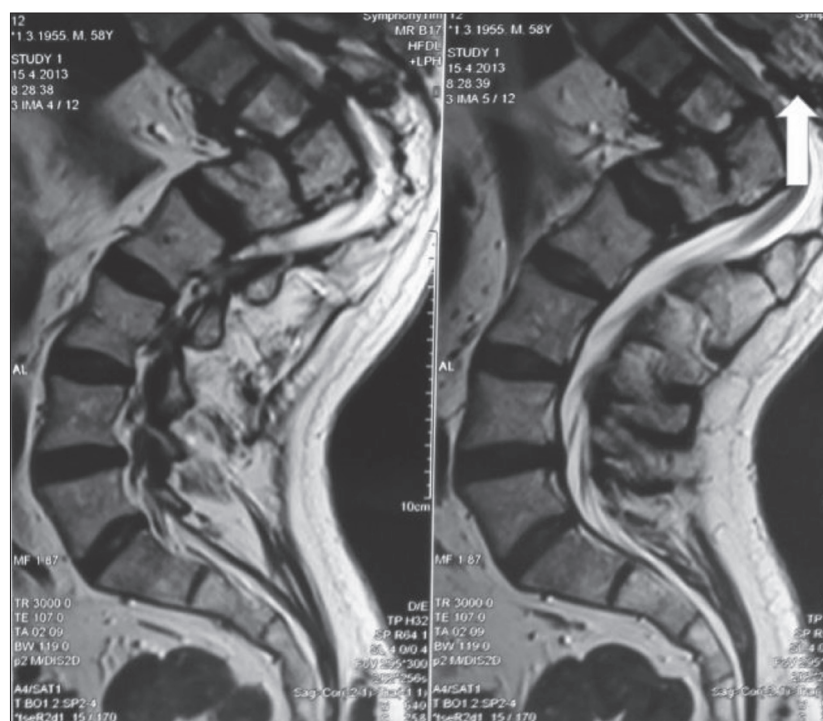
T2 weighted magnetic resonance imaging of the thoracolumbar spine showed pronounced kyphosis with signs of spinal canal stenosis most pronounced at the level of Th11–Th12 with the consequent myelopathy finding, due to hypertrophied yellow ligament at the same level (arrow)
